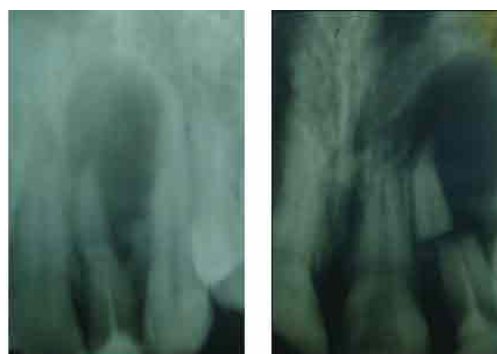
Pre-operative radiograph with different angulations years. Clinical examination revealed that it was mildly tender to percussion. Radiographically, a horizontal root fracture was present in the middle third of the upper left lateral incisor together with a periapical radiolucency surrounding the fractured apical part. There were no significant pocket depths and no evidence of sinus tracts. The adjacent teeth were non tender and responded normally to cold.
